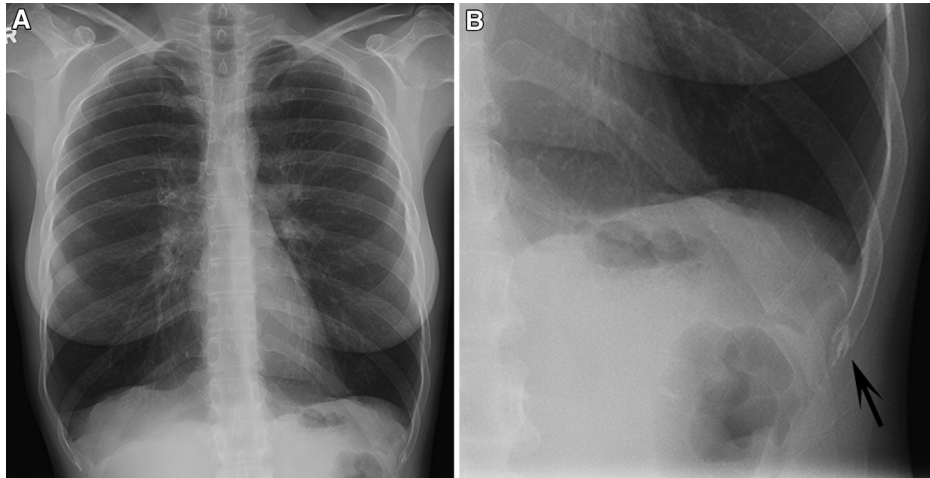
Normal chest radiograph (A) of a 24-year-old woman clearly reflects gender-related features due to prominent breast shadows. Also, note characteristic central pattern of costal cartilage calcification (arrow) seen on coned down and zoomed-image (B).
